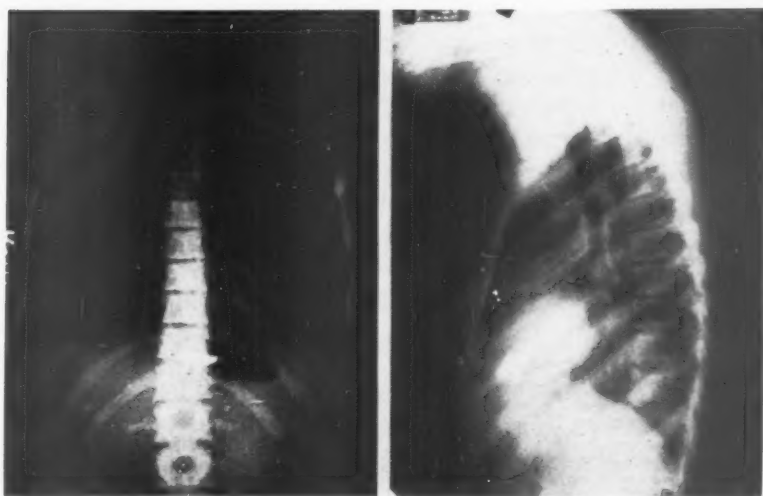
Posteroanterior and lateral roentgenograms showing a foreign body in a pericardial abscess.
